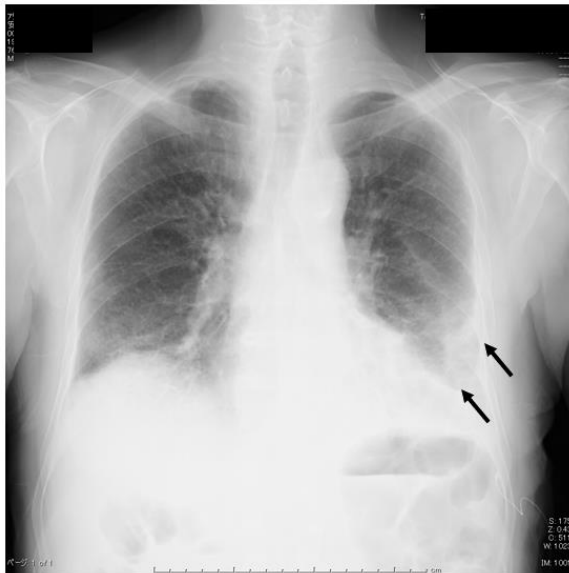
Chest X-ray findings of a 68-year-old man with influenza pneumonia (A). *Haemophilus influenzae* was also isolated from his sputum, suggesting influenza-related bacterial pneumonia. Unilateral infiltration shadows are seen in the left lower lung (arrows), and he improved with peramivir and sulbactam/ampicillin treatment.
